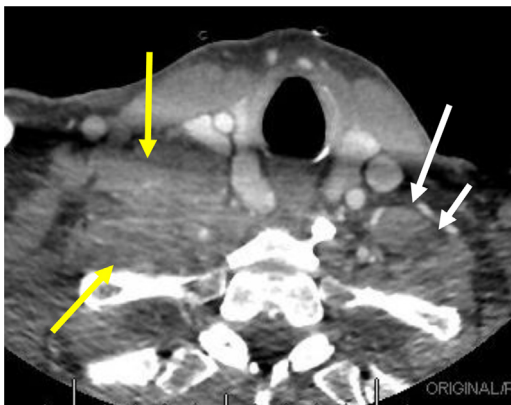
SCCA invasion of brachial plexus. Axial contrast-enhanced CT shows normal appearance of the left anterior scalene (long white arrow) and supraclavicular brachial plexus (small white arrow). There is a large mass invading the right brachial plexus characterized by an invasion of the anterior scalene and supraclavicular brachial plexus (yellow arrows).
